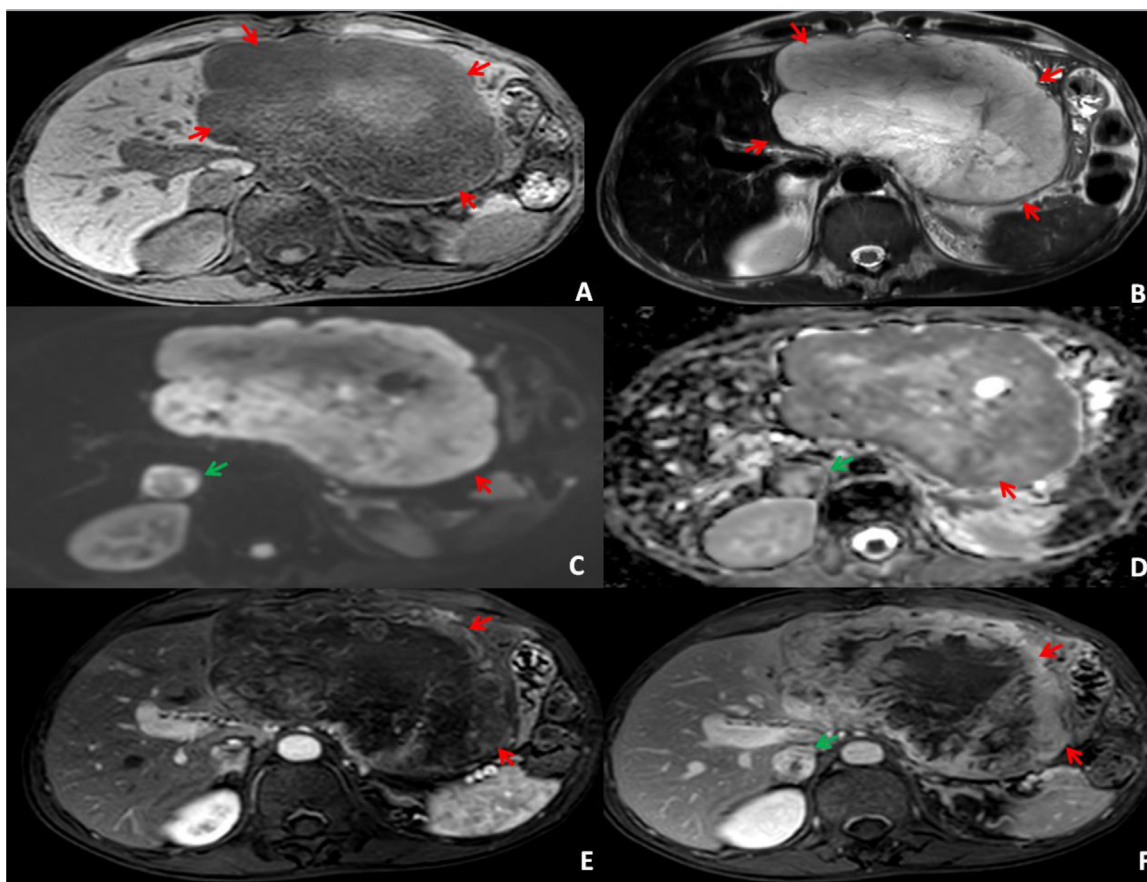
MRI findings of primary liver leiomyosarcoma. (A) On T1-weighted imaging (WI), the mass (red arrow) is well defined and shows slightly a heterogeneous hypointensity. (B) On T2WI, the mass (red arrow) is heterogeneously hyperintense. (C and D) On diffusion-WI, the mass (red arrow) display hyperintensity. (E) In the arterial phase of dynamic contrast-enhanced imaging, the mass (red arrow) shows no evident enhancement. (F) In the 3-min delayed imaging, the mass (white arrow) shows a heterogeneous marked enhancement. The adrenal gland (green arrow) metastasis is also enhanced.
